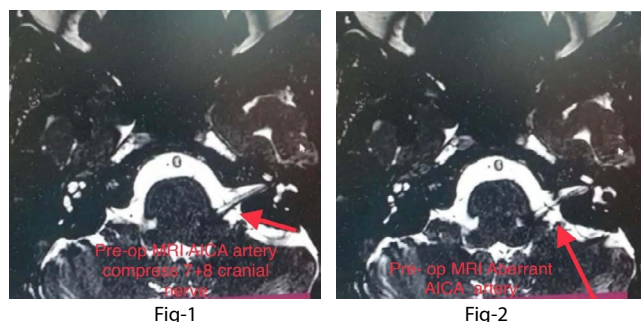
Preoperative MRI showing aberrant AICA artery compressing the vestibulocochlear and the facial nerve.
